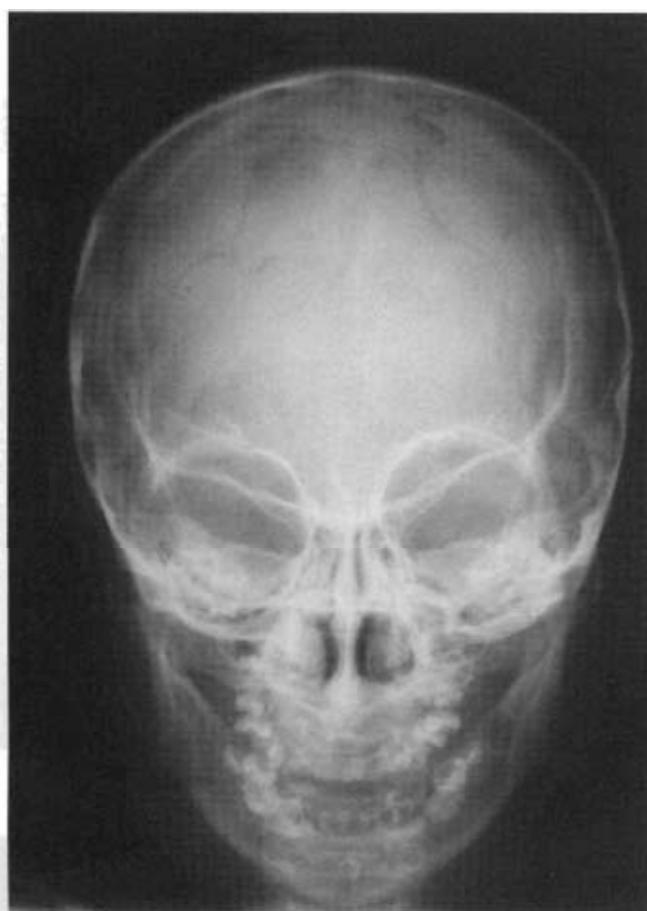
Patient 1 (a) lateral cephalograph. Note increased digital marking of the skull. b: Panoramic radiograph. Supernumerary right maxillary permanent molar. Patient 2 (c) PA skull radiograph. d: Panoramic radiograph. Note single-rooted or rootless molars, severe microdontia of developing permanent premolars and molars, severely hypoplastic alveolar bone, and molar crowns converge occluso-cervically.
